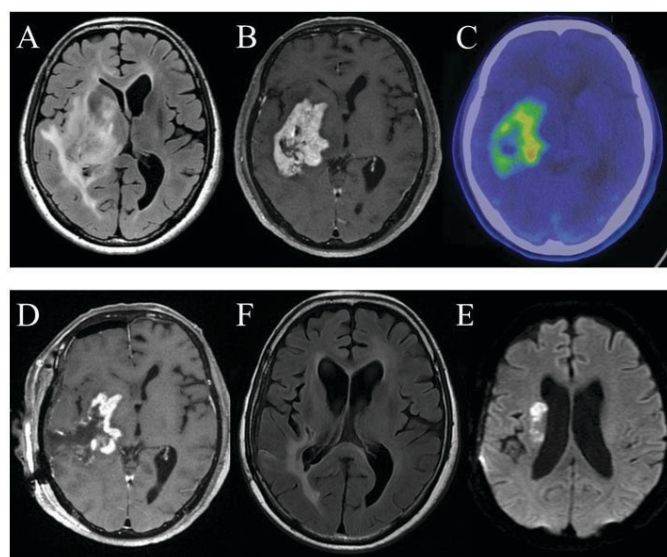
(A) The head magnetic resonance imaging (MRI) with fluid-attenuated inversion recovery (FLAIR) at the time of admission. (B) The gadolinium-enhanced T1-weighted MRI image at the time of admission. (C) A methionine accumulation image obtained via positron emission tomography (PET). (D) The gadolinium-enhanced T1-weighted MRI image after surgery. (E) The FLAIR image prior to the 16th bevacizumab treatment. (F) The diffusion-weighted image when the ischemic stroke occurred.
